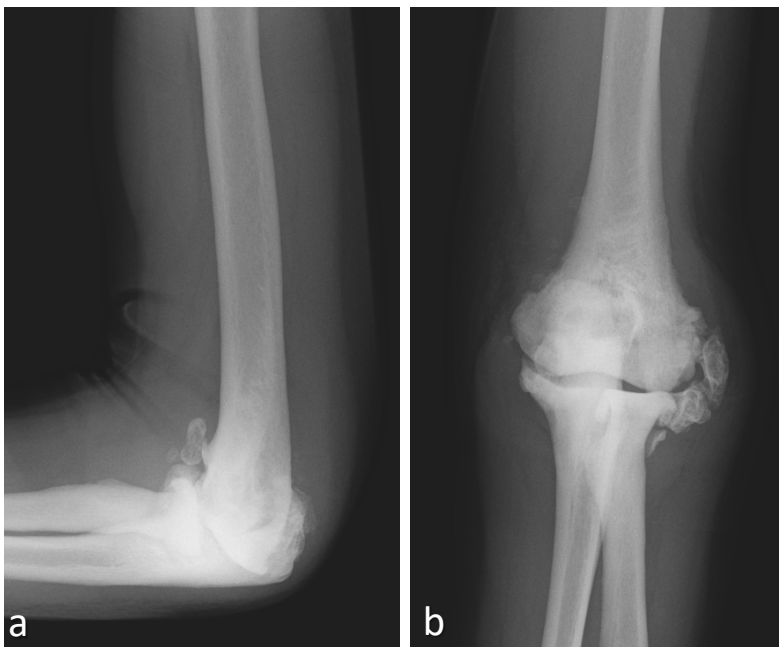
Radiographic study of the left elbow in two views. Radiographs show marked joint deformity with sclerosis and fragmentation, associated with thickening and densification of soft tissues. These aspects represent hypertrophic neuroarthropathy of the elbow.
